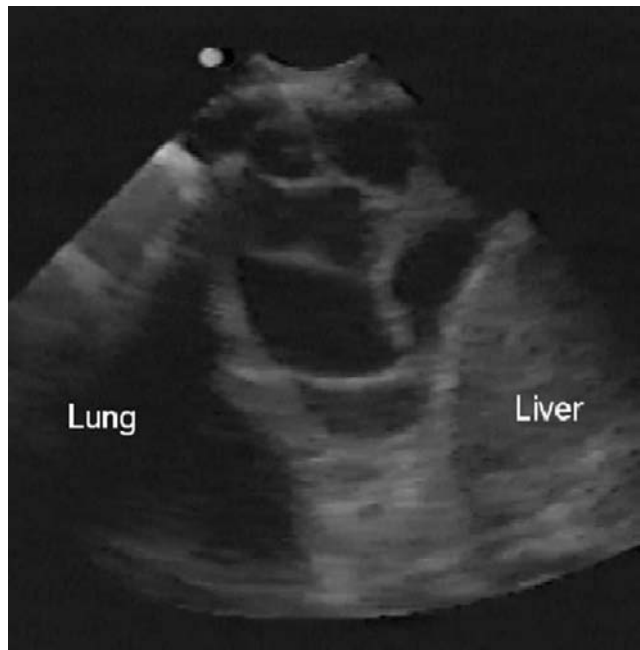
A complex, septate pleural effusion demonstrated by ultrasonography in a patient with spontaneous hemorrhage into a pre-existing pleural effusion. This precise pattern is typical of a complicated parapneumonic effusion as well. (Reprinted from [13] with permission.)
